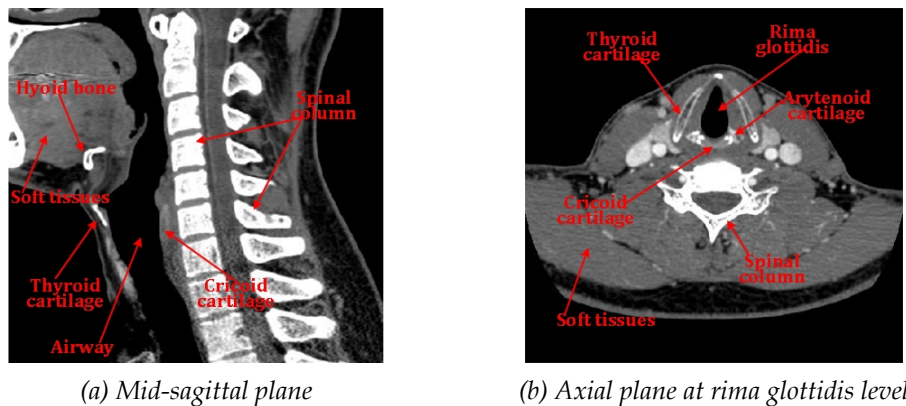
Different structures on a laryngeal CT image
